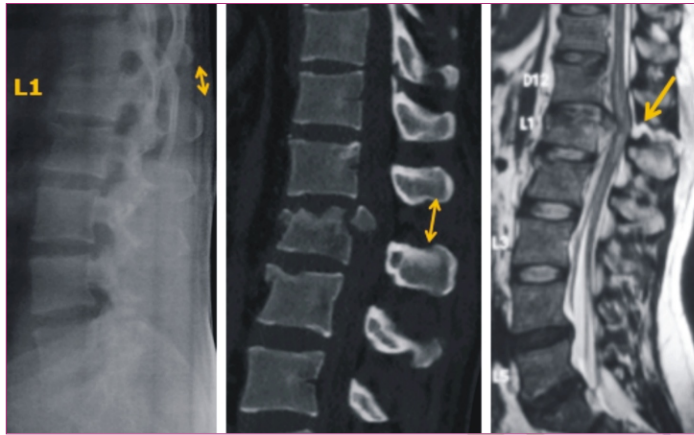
Radiograph and CT scan showing the interspinous widening. MRI T2W images showing break in the black line of PLC (ligamentum flavum, interspinous and supraspinous ligaments). [TLICS= distraction injury 4 + PLC disrupted 3 + incomplete conus injury 3].
